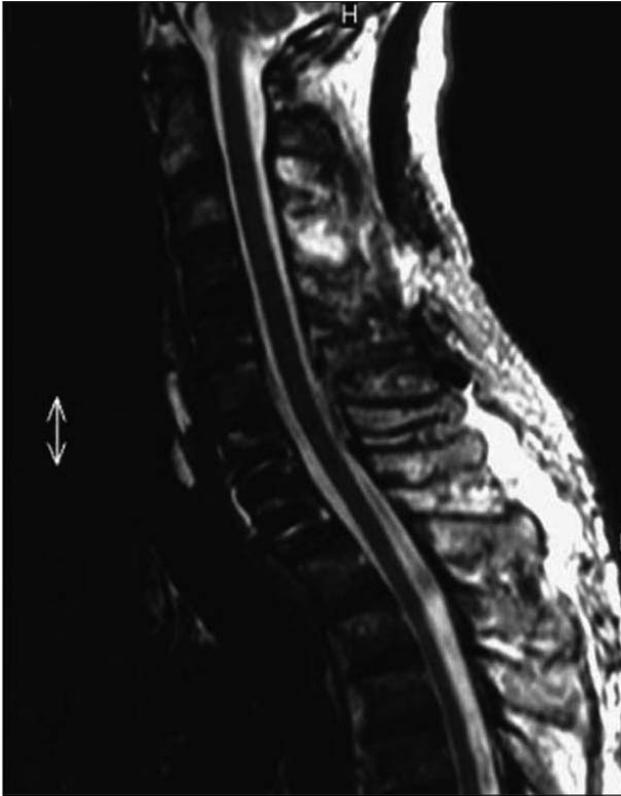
MRI showed successful alignment of the cervicothoracic junction after the operation.
